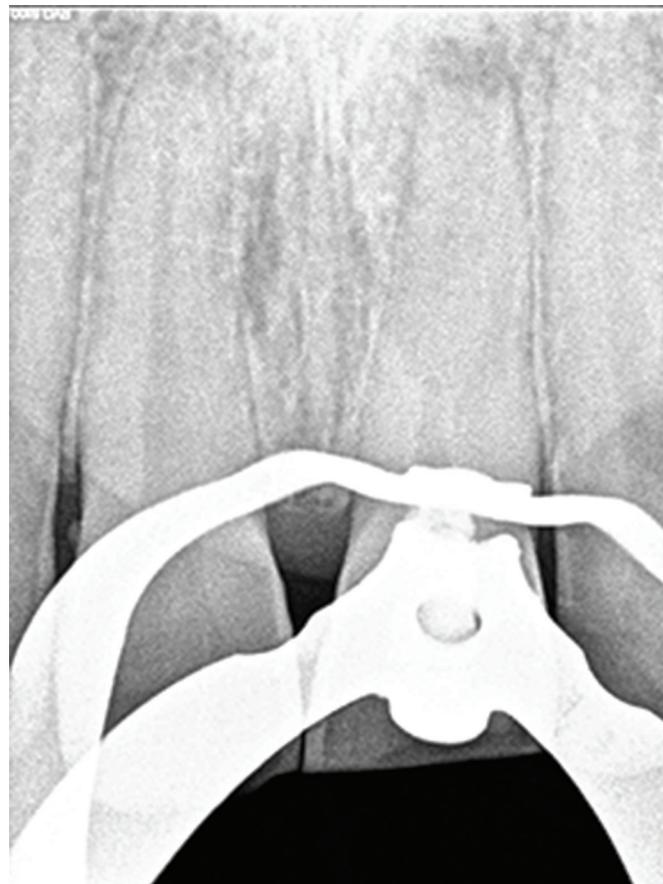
Intraoral periapical radiograph showing dense calcium hydroxide medication placed in 21
